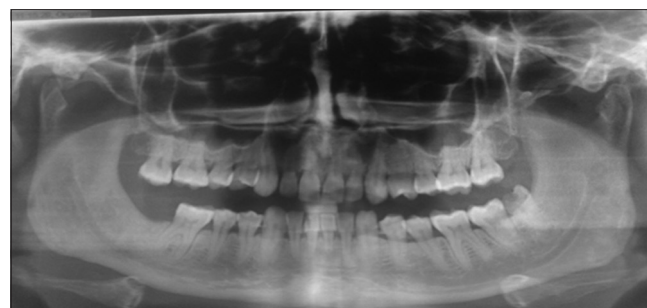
Thirteenth-month postoperative panoramic radiograph showing missing 47, 48 with no pathology on the right side of mandible
